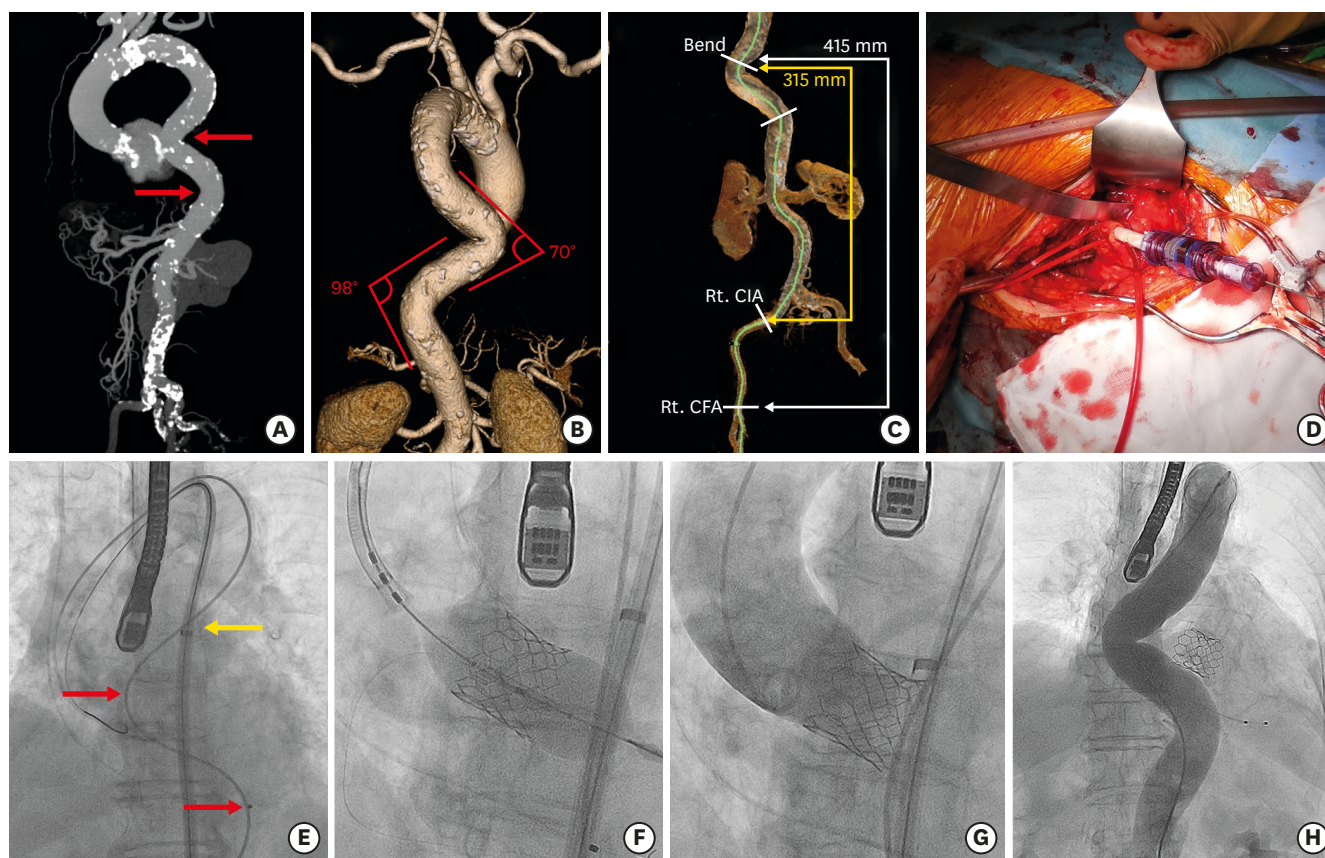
(A-C) Pre-procedural MDCT (A) Left anterior oblique view of maximum intensity projection showing a markedly tortuous thoracic aorta and no significant calcification around the acute bend (red arrows). (B) Posterior volume-rendering image of the aorta. (C) Volume-rendering image of the aorta showing the distance from the Rt.CFA (white bidirectional arrow) and the Rt.CIA (yellow bidirectional arrow) to the acute bend in the thoracic aorta. (D) Direct iliac approach. (E-H) Fluoroscopic images during the procedure. (E) Facilitating smooth insertion of the eSheath (yellow arrow) beyond the tortuous segment of the thoracic aorta (red arrows). (F) Successful implantation of the prosthetic valve. (G) Aortography showing trivial paravalvular leak. (H) Final aortography showing no vascular complication. MDCT = multi-detector computed tomography; Rt.CFA = right common femoral artery; Rt.CIA = right common iliac artery.
